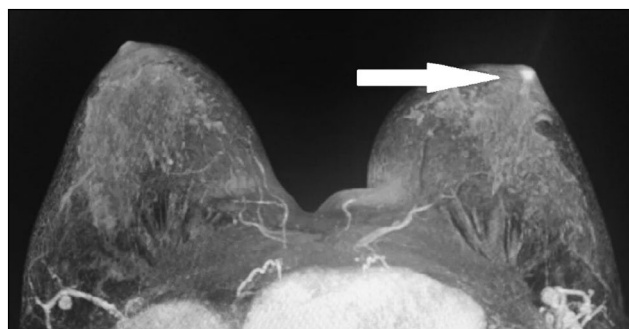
Magnetic resonance imaging (MIP): asymmetric contrast accumulation in the left nipple; normal finding (arrow).
